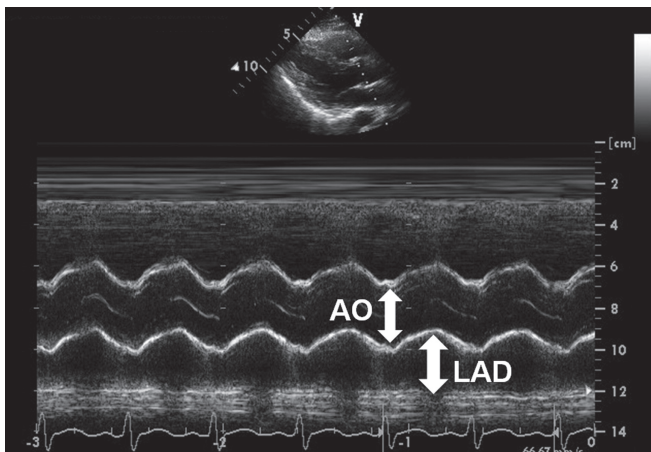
Measurement of the left atrial diameter from M-mode, guided by a parasternal long-axis view (upper half). AO= aorta, LAD= left atrial diameter.
